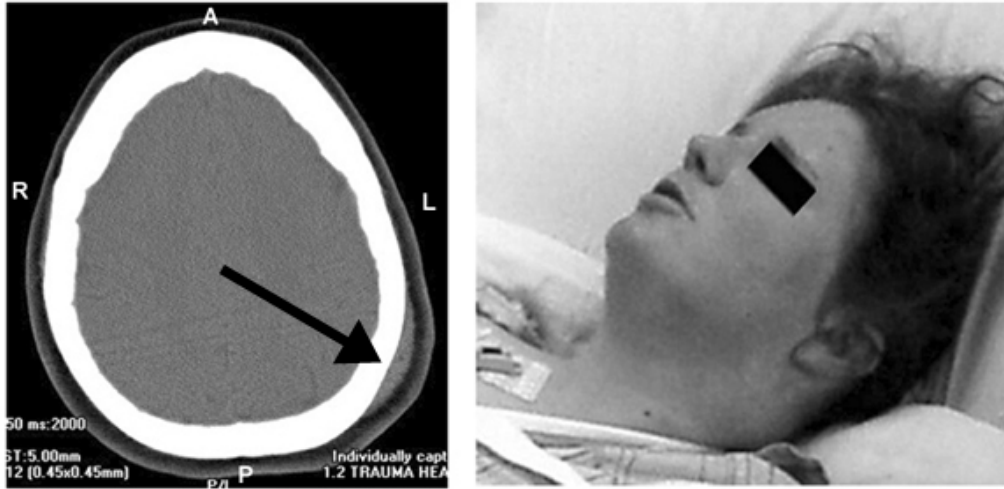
Transverse CT scan image of the subject's head shows a sizable contusion and hematoma over the left lateral posterior aspect of the skull. No corresponding abnormality was noted on physical examination or subject photograph.
